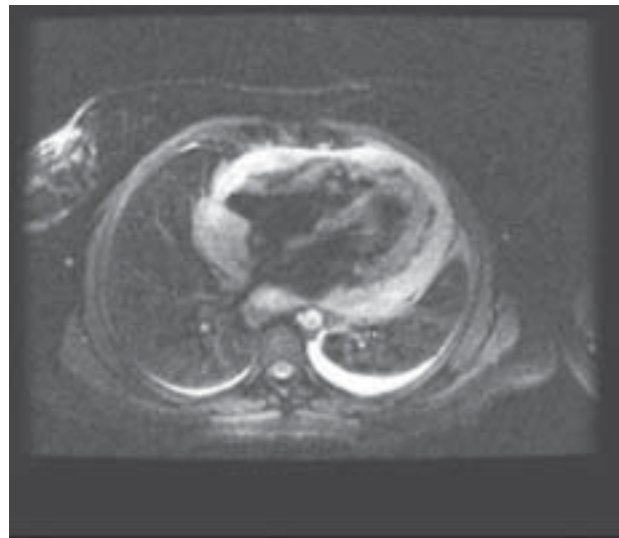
MRI T2 FATSAT sequence, which shows the same mass, now hyperintense, in the same location as described in Figure 2
